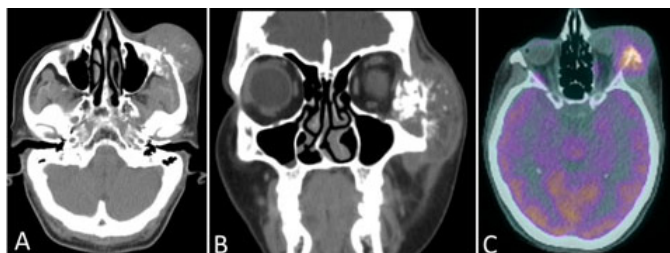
A) preoperative CT scan with contrast, showing a 49x36 mm osteolytic lesion of the cheekbone (axial view); B) preoperative CT scan with contrast, coronal view; C) pre-operative PET-CT.
